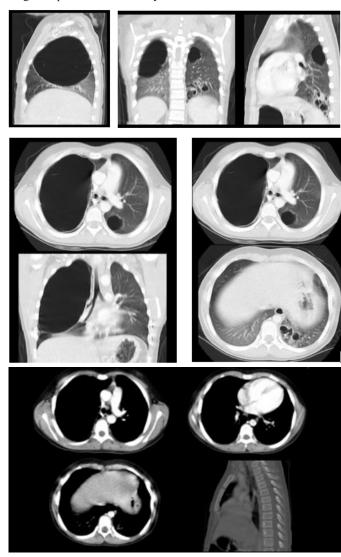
CT Scan Approximate volume of 636 cc.
